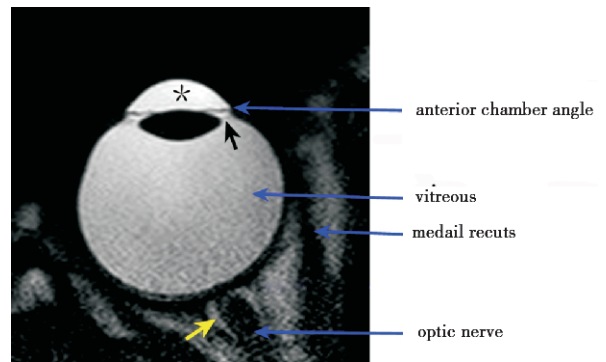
Axial SSh-TSE sequence T₂WI HR-MR image. The structure of anterior chamber are depicted, as well as iris (black arrow) and anterior chamber angle, optic nerve sheath (yellow arrow), anterior chamber (asterisk).
